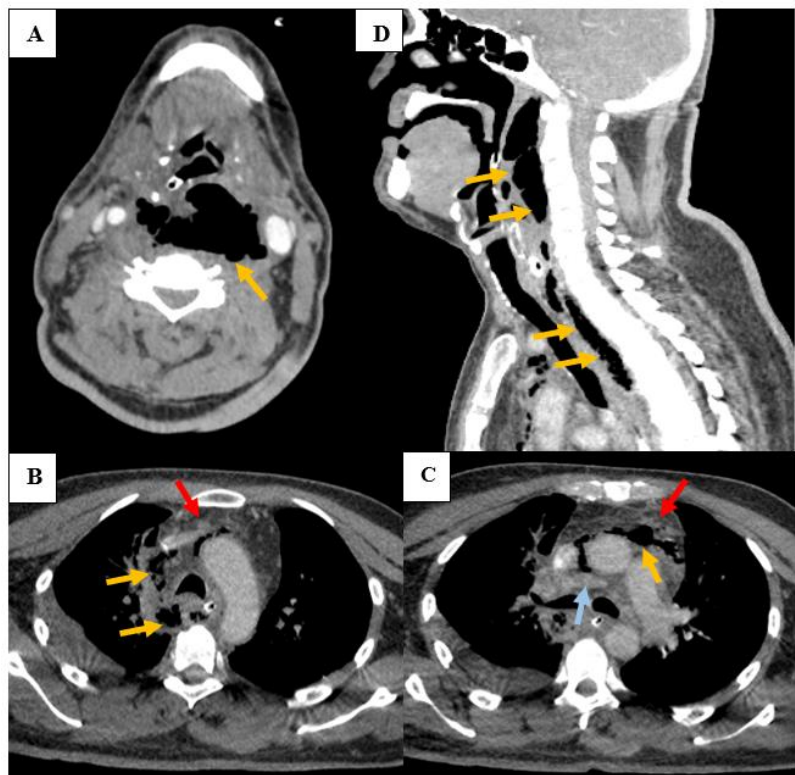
Follow-up axial (A, B, C) and sagittal (D) CT scan of the neck and chest revealing diffuse extension of the initial retropharyngeal abscess (Figure 1) downward through the cervicothoracic junction, involving all mediastinal compartments (yellow arrows), characterized by extensive air bubbles, mediastinal fat infiltration (red arrows) and lymphadenopathy (blue arrow)
